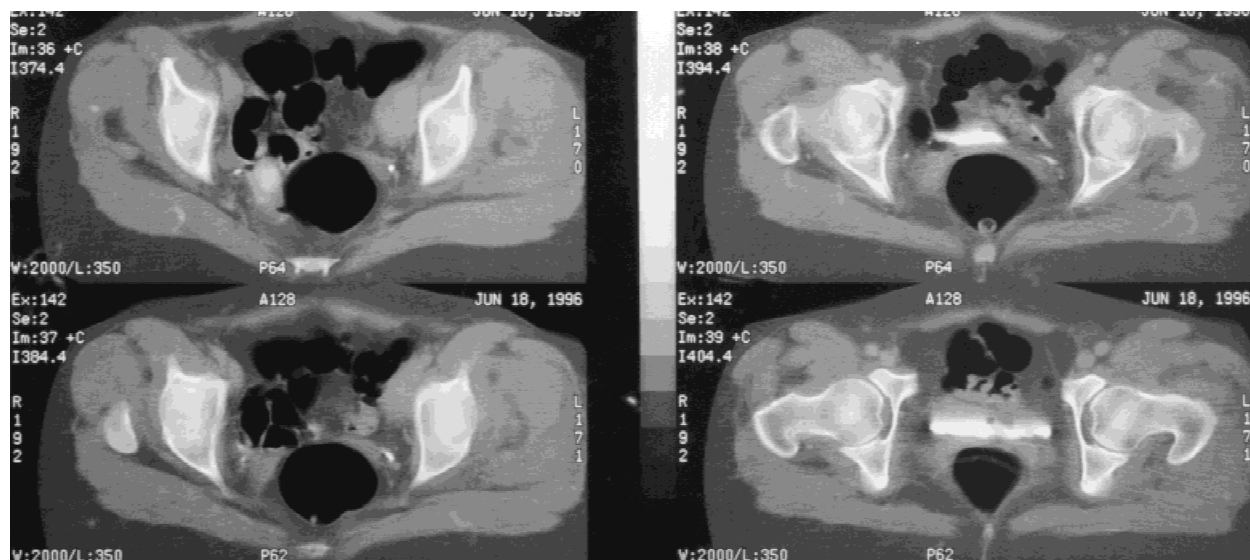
A pelvic mass incidentally found by CT. An iliac vein aneurysm was confirmed by MRI and duplex ultrasonography.
